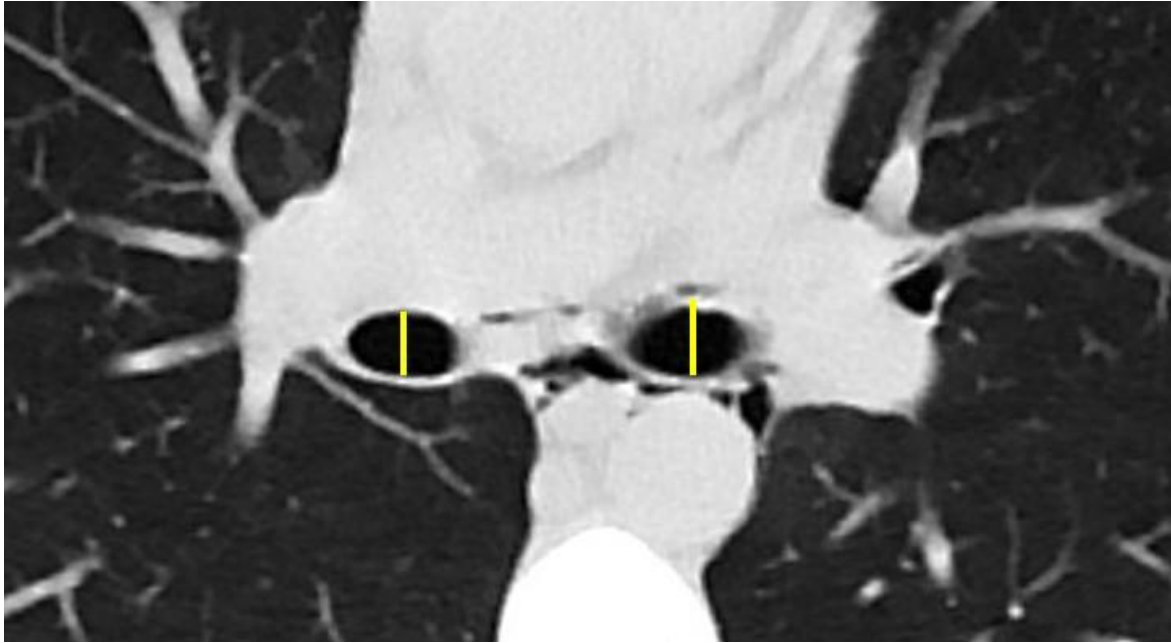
Measurement of AP diameters of the main bronchi on an axial CT image, 2 cm distal to the carina
